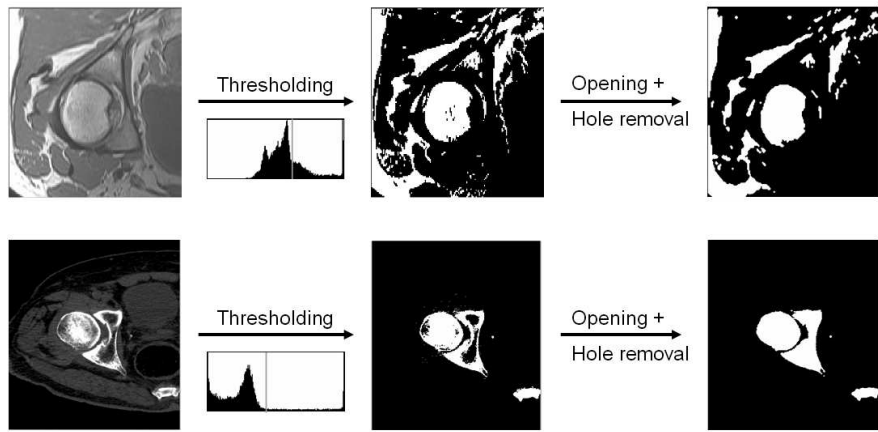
Histogram analysis for bone segmentation from MRI (top) and CT (bottom)
